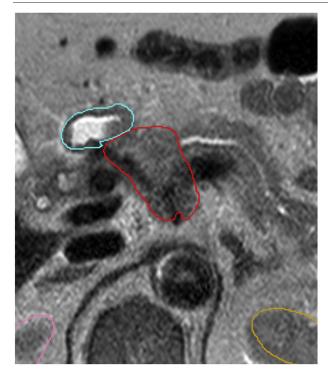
T2-weighted image, an example of gross tumor volume in red and duodenum in turquoise. (Color version of figure is available online.)
